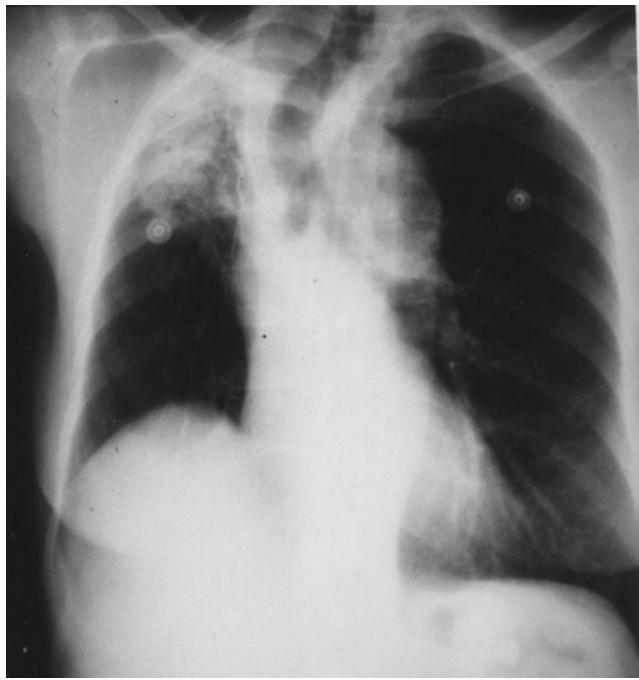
Preoperative chest X-ray of a patient with a history of previous tuberculosis, right upper lobectomy, and recent hemoptysis presenting for right thoracotomy possible completion pneumonectomy. The potential problems positioning a left-sided double-lumen tube in this patient are easily appreciated by viewing the X-ray but are not mentioned in the Radiologist's report. The Anesthesiologist must examine the chest imaging him/herself preoperatively to anticipate problems in lung isolation.
